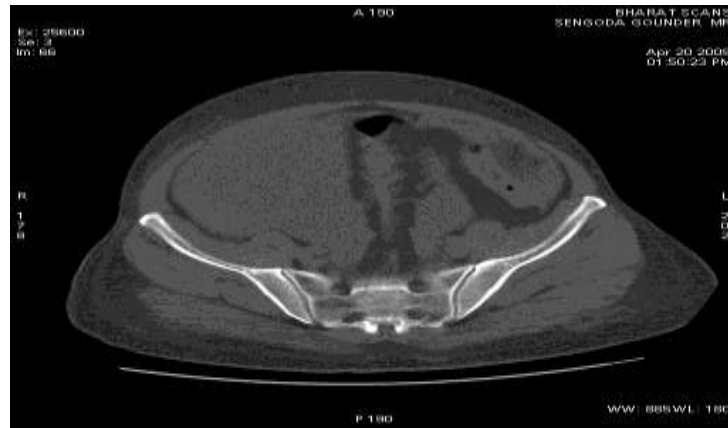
Normal CT- image of SIJ
